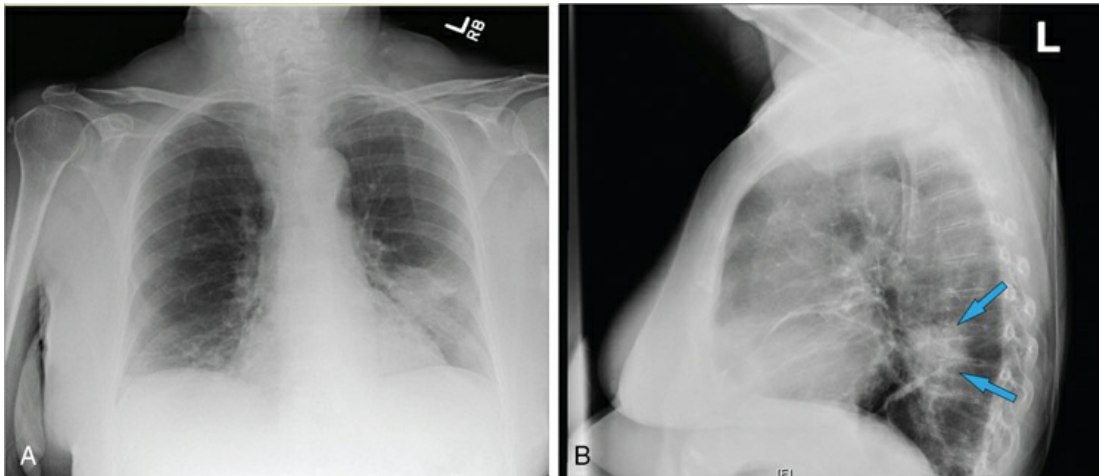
A, Posteroanterior (PA) chest radiograph shows adenocarcinoma presenting as a left lower lobe mass. B, Lateral chest radiograph of the same patient shows the mass posterior to the cardiac silhouette (arrows).
